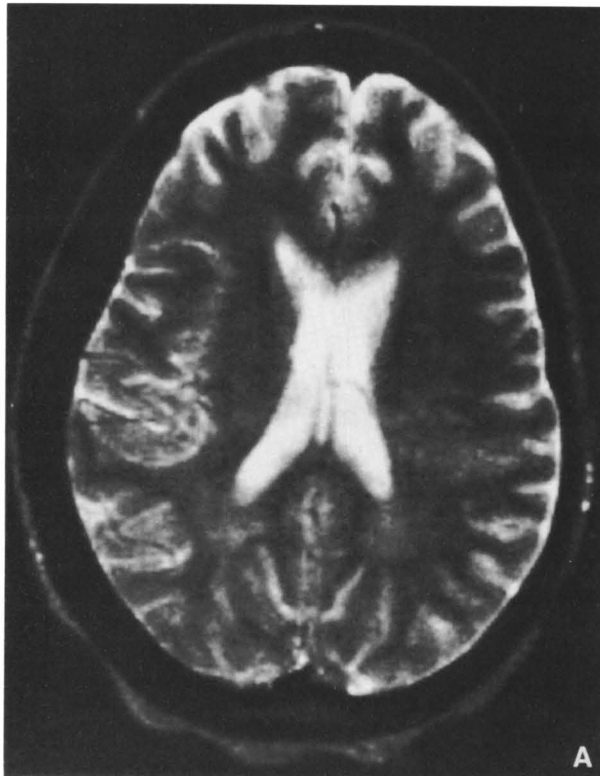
Abnormal brain magnetic resonance imaging scans of patients with TSP/HAM. T2-weighted sequences showing the high-signal lesions in the cerebral white matter. Panel A. Axial image of the brain of a 34-year-old woman from Central Africa with a 3-year history of TSP/HAM. Panel B. Axial image of the brain of a 36-year-old woman from Martinique (French West Indies) with a 13-year history of TSP/HAM. Panel C. Coronal image of the brain of a 63-year-old woman from Guadeloupe (French West Indies) with a 9-year history of TSP/HAM.
